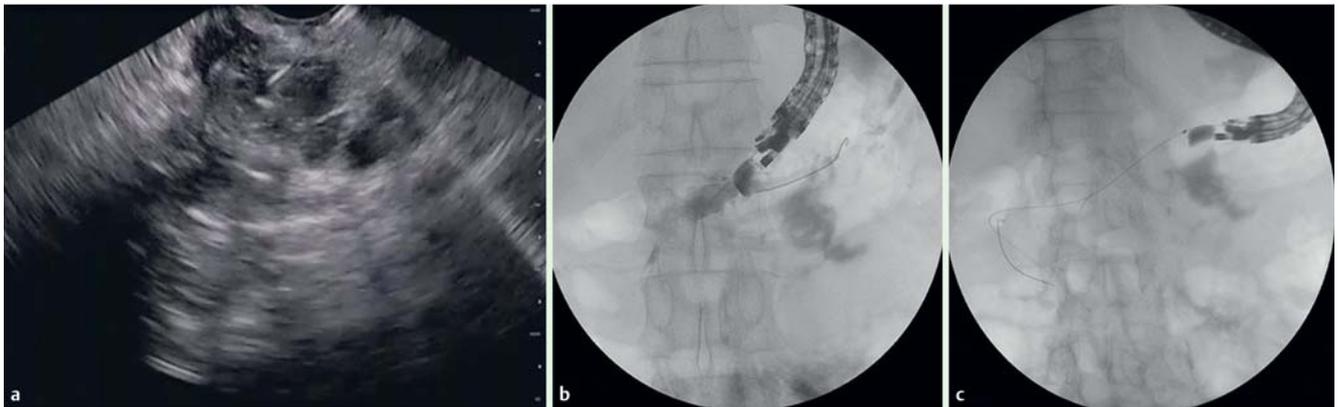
a Endoscopic ultrasound (EUS) shows the 19G needle inside the main pancreatic duct. b EUS-guided pancreatography and the insertion of the guidewire. c Passage of the guidewire through the minor duodenal papilla.
